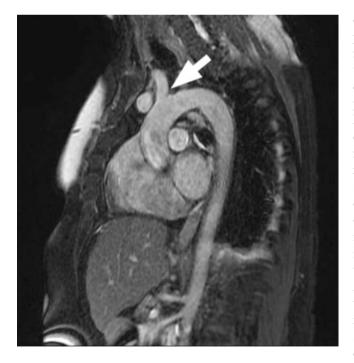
Sagittal T2-weighted image from a non-contrast MRI depicts the normal aorta and origin of the left subclavian artery (arrow) in detail
